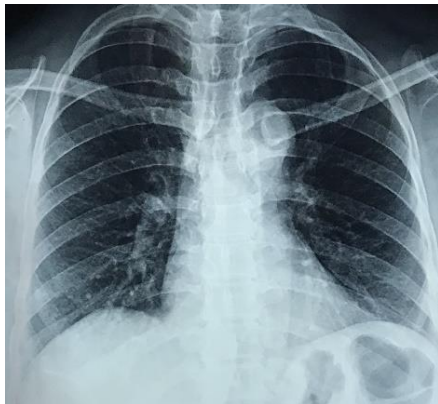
chest x-ray posteroanterior view showing normal lung parenchyma
